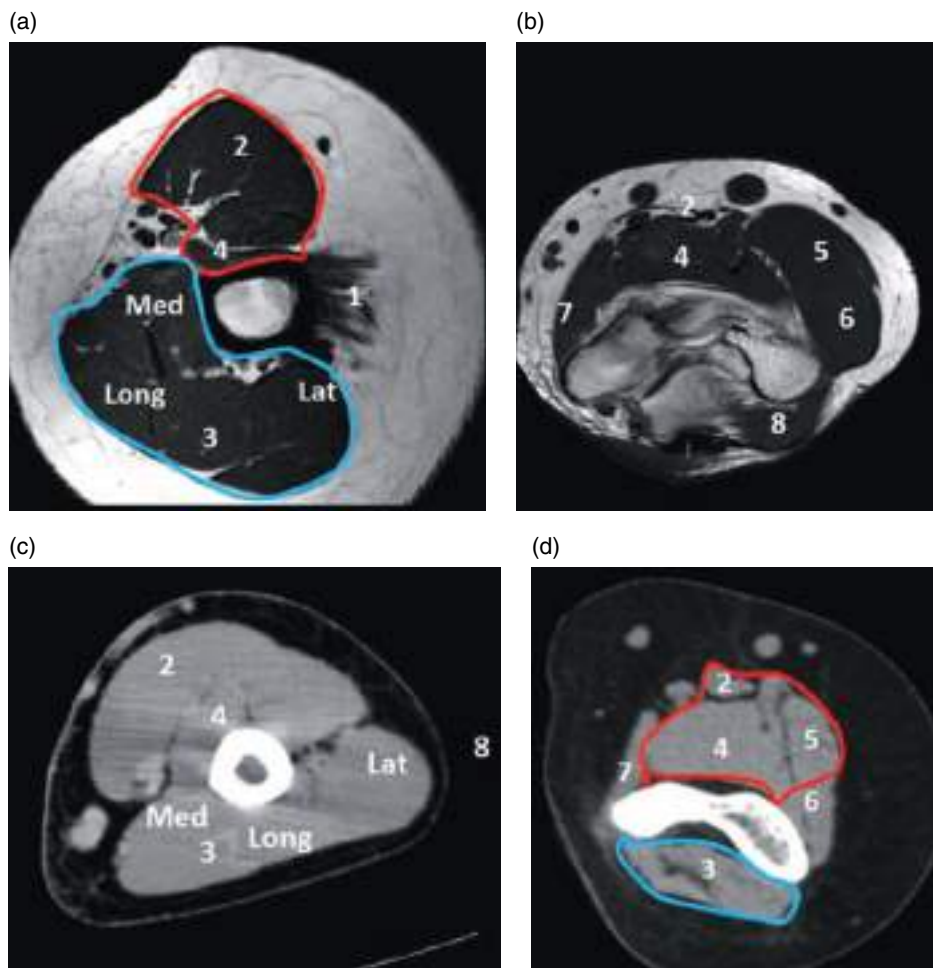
Arm compartments. Axial T1 MR sequence of the proximal (a) and distal (b) arms. CT scan of the proximal (c) and distal (d) arms. 1, deltoid; 2, biceps; 3, triceps (long, medial, and lateral heads); 4, brachialis; 5, brachioradialis; 6, extensor carpi radialis longus; 7, pronator teres; 8, anconeus; red, anterior compartment; blue, posterior compartment.
